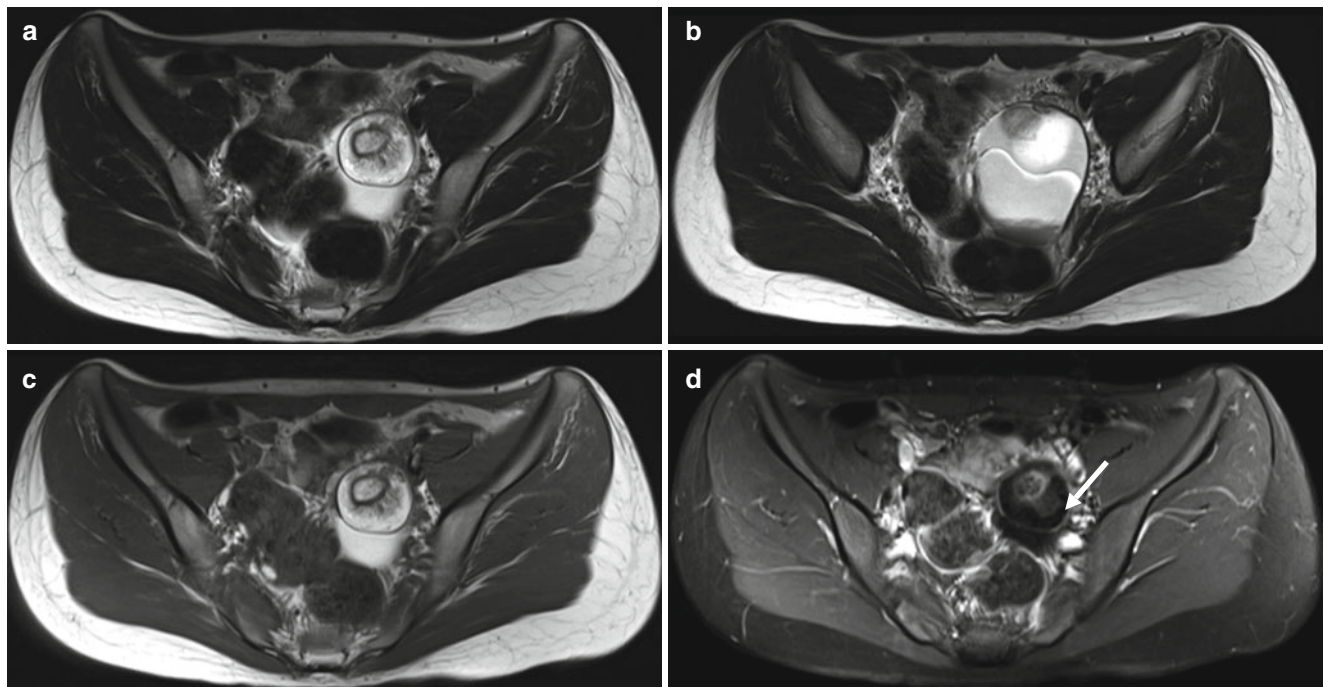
Mature cystic teratoma in a 16-year-old girl. Axial T2-weighted (a, b) and T1-weighted (c) MR images show left ovarian cystic mass containing fat, calcification, and mural nodule.
